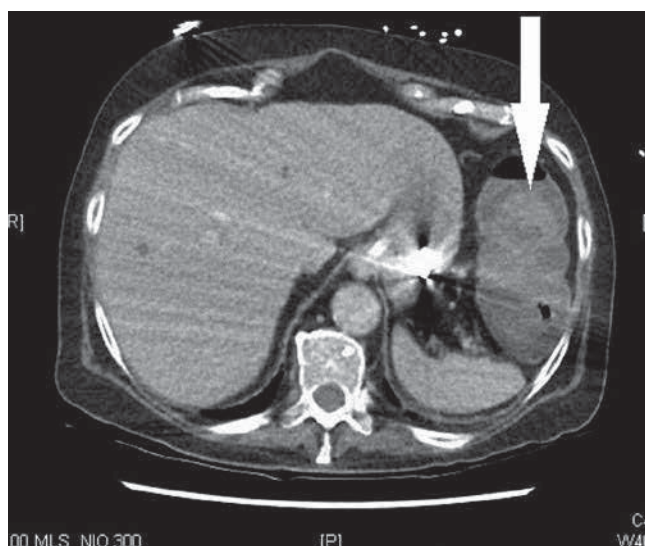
CT abdomen. Arrow shows area of ischemic colitis.
